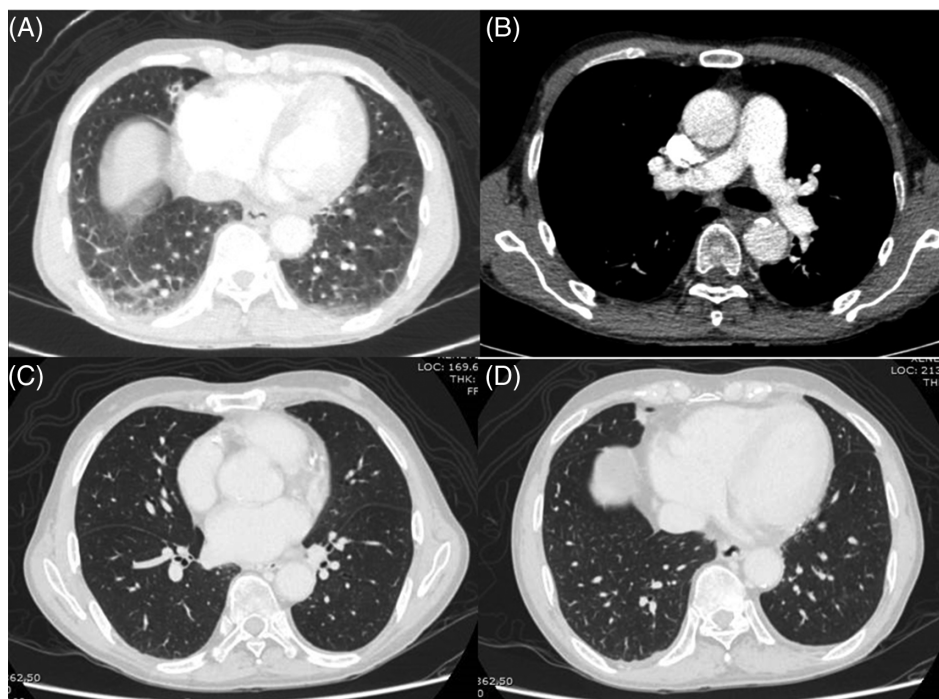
Computed tomography angiography of chest revealed sub-pleural reticulation at bilateral lower lobes (A) without pulmonary embolism (B). After definitive treatment, computed tomography of chest revealed complete resolution of sub-pleural reticulation (C, D).
